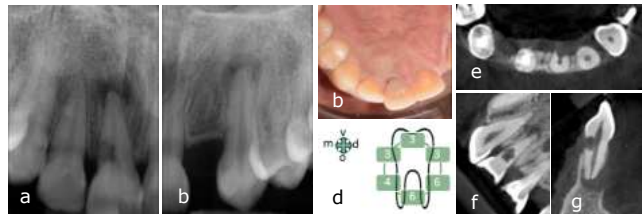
+ b. preoperative radiographs of the teeth 11, 21 and 23 c. preoperative picture d. periodontal status of tooth 21 e. + f. + g. preoperative CBCT cross section images
